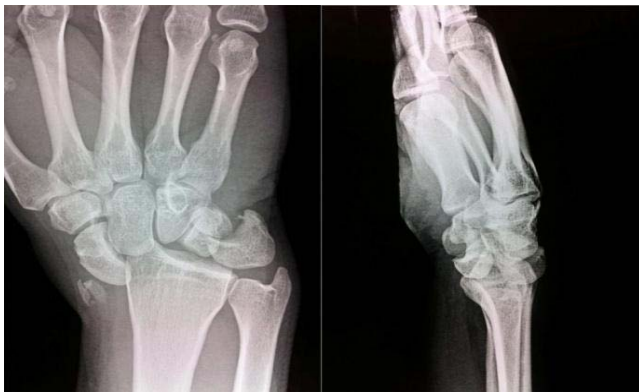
Pre-operative X-rays.
